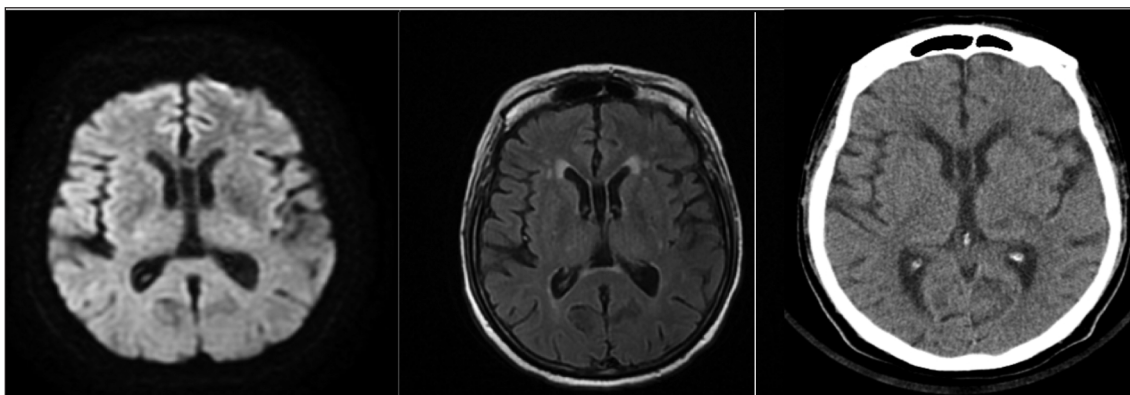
Basal ganglia hypodense/hyperintensity disappeared on diffusion MRI and CTI on the tenth day.
